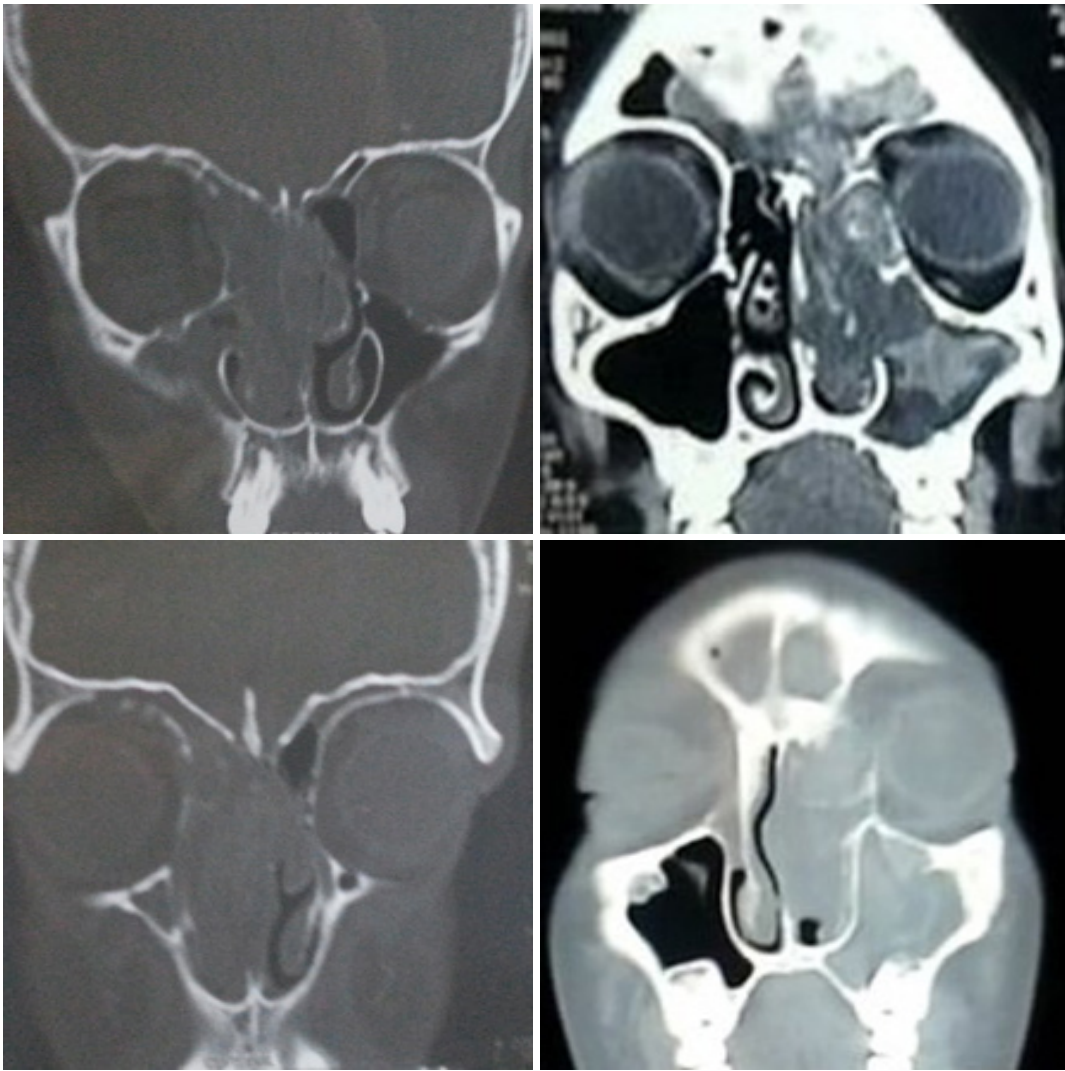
preoperative coronal CT showing AFS
